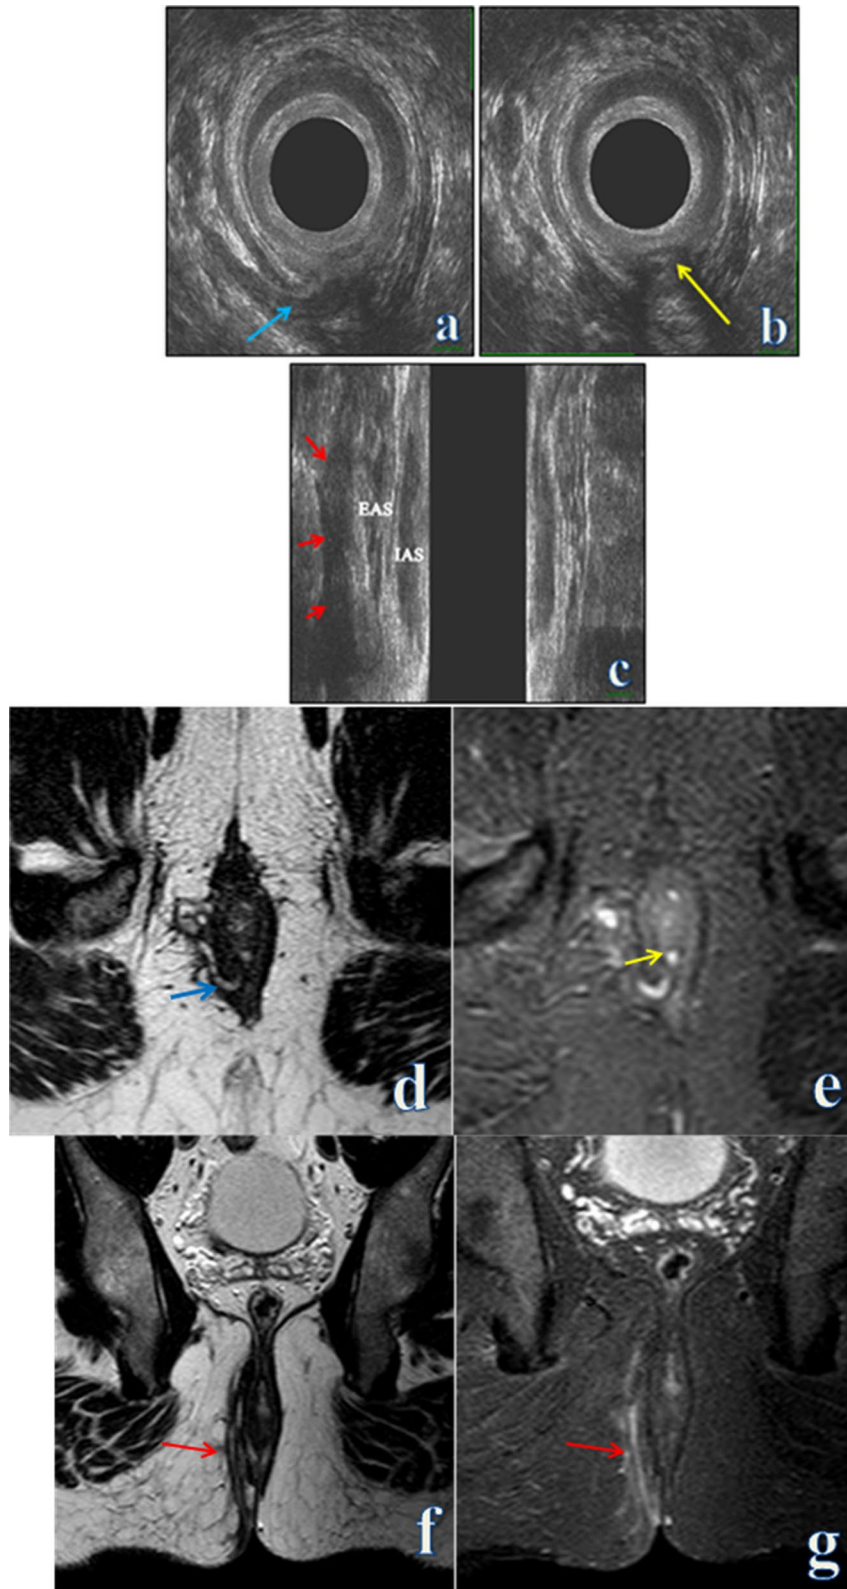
a, b axial and c coronal reconstructed EAUS images show trans-sphincteric hypoechoic (red arrows) fistulous track, traversing EAS at 7 O'clock (blue arrow) and IAS at 6 O'clock (yellow arrow), d axial T2WI, e axial STIR, f coronal T2WI and g coronal STIR MRI images show a right sided fluid filled trans-sphincteric fistula, eliciting high T2/STIR SI (red arrows),traversing EAS at 7 O'clock (blue arrow) and IAS at 6 O'clock (yellow arrow)
